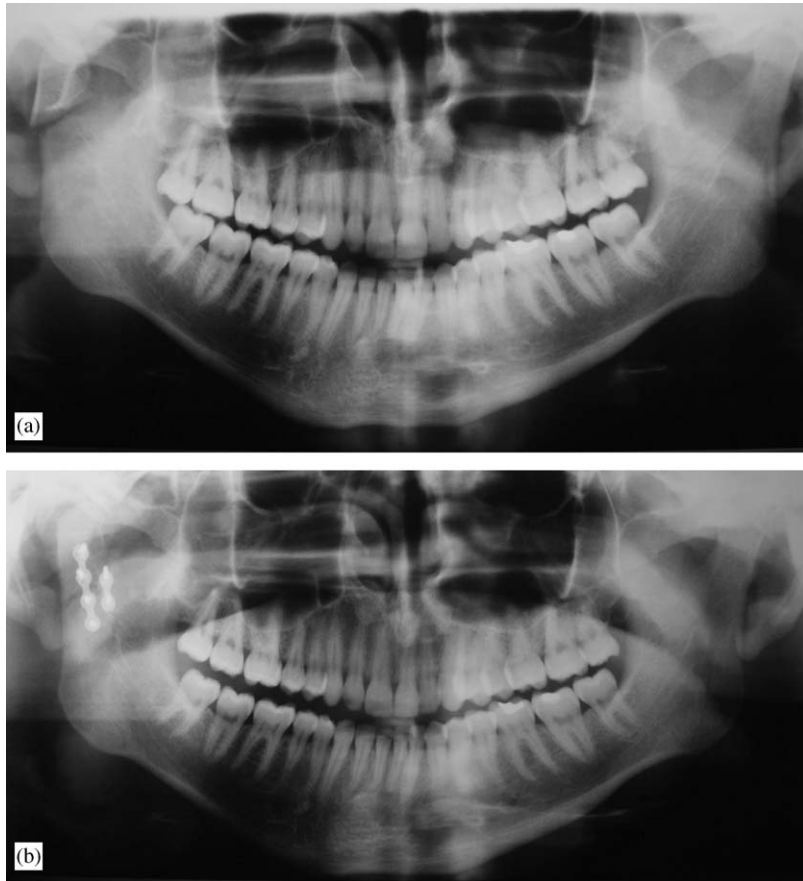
Right-sided fracture dislocation at condylar neck level (p.a. views are not shown). (a) Pre- and (b) postoperative orthopantomograms, reduction is anatomical, condylar height restored, fracture fixed with two 2.0 mm miniplates and screws (same patient).
